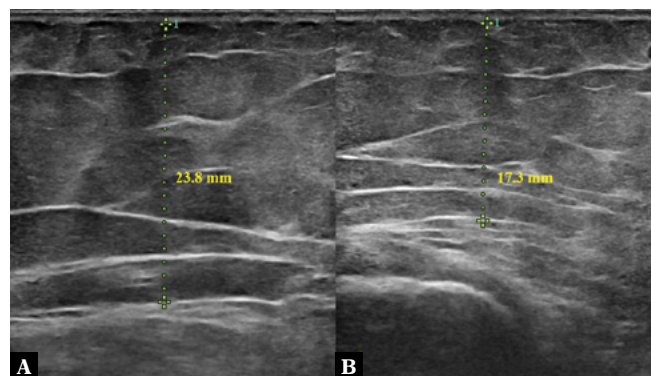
Ultrasonographic assessment of the subcutaneous tissue using conventional ultrasonography. A. Before treatment. B. After treatment (evident thickness reduction)
